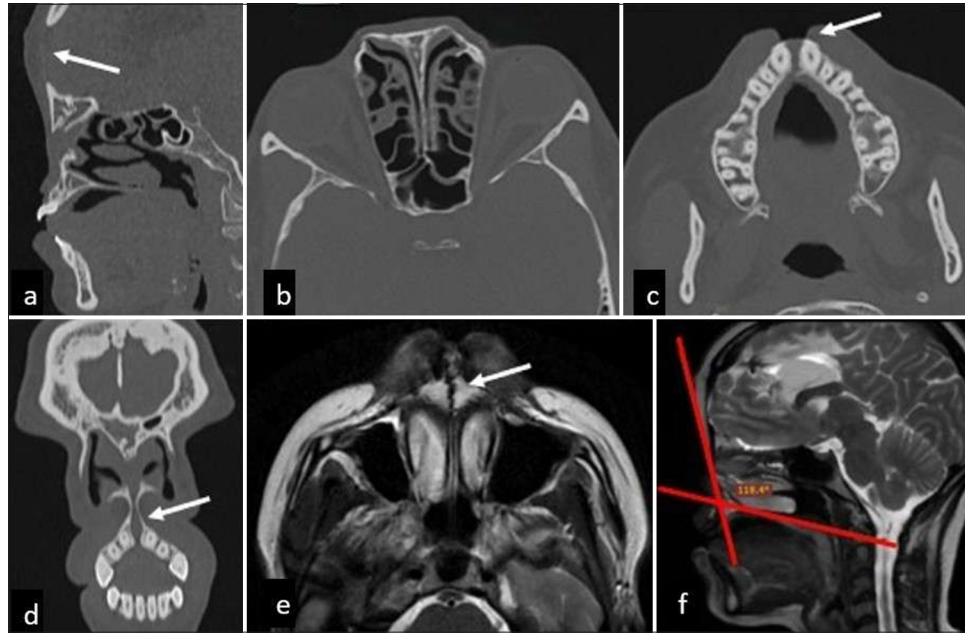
Frontonasal dysplasia. (a) CT sagittal section shows calvarial defect in the anterior frontal bone (white arrow) with no evidence of cephalocele. (b) CT axial image shows widening of bilateral ethmoidal sinuses and nasal cavities with associated hypertelorism. (c,d,e) Axial and coronal CT sections and MR axial section show midline cleft involving upper lip and palate (white arrows). (f) MR sagittal section demonstrates frontonasal dysplasia with flattening of the midface and a widened fronto-maxillary angle measuring $\sim 118^\circ$.
